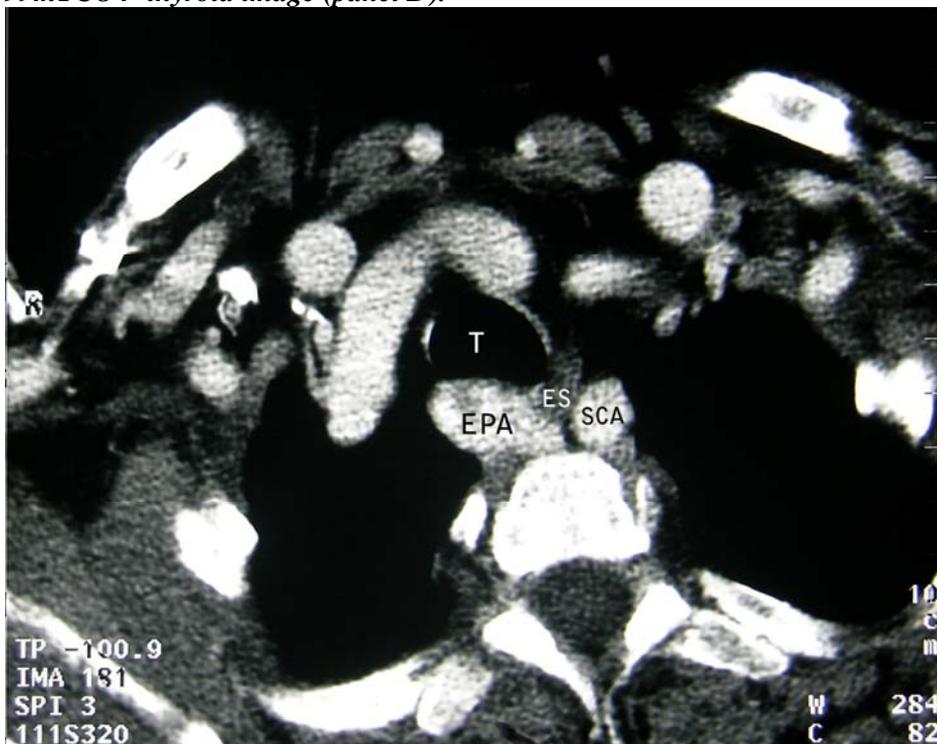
CT scan of the superior mediastinum with intravenous contrast showing the ectopic parathyroid adenoma (EPA) posterior to the trachea (T) and to the right of the esophagus and left subclavian artery (SCA).
